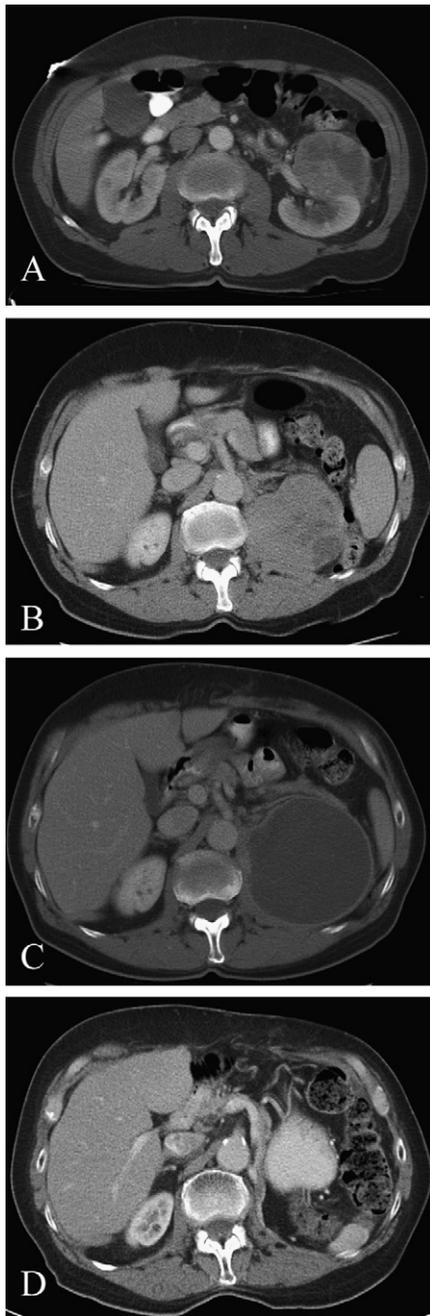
Serial computed tomography (CT) scans in a 70-year-old man with renal cell carcinoma (RCC). (A) In August 2000, he underwent nephrectomy for a 10-cm Grade 4 RCC of the left kidney. (B) In April 2002, he developed an 8-cm recurrence in the left prevertebral region. After biopsy confirmation, he received preoperative external beam radiotherapy (45 Gy in 25 fractions). (C) In July 2002, repeat CT scan 4 weeks after completion of radiotherapy revealed extensive treatment effect. At the time of resection, the medial margin was initially positive on intraoperative frozen section examination; however, after re-excision, all final margins were negative. Intraoperative radiotherapy (10 Gy) was delivered to the medial margin against the vertebral body, aorta, and inferior vena cava. (D) As of February 2010, he has remained free of disease.
